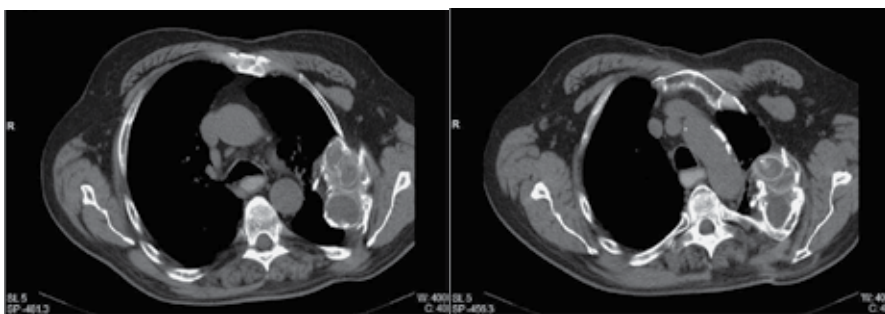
CT aspect of an 81 years-old patient who underwent a plombage thoracoplasty 46 years ago for left upper lobe tuberculosis. The patient presented no TB recurrence and no chest complaints.
